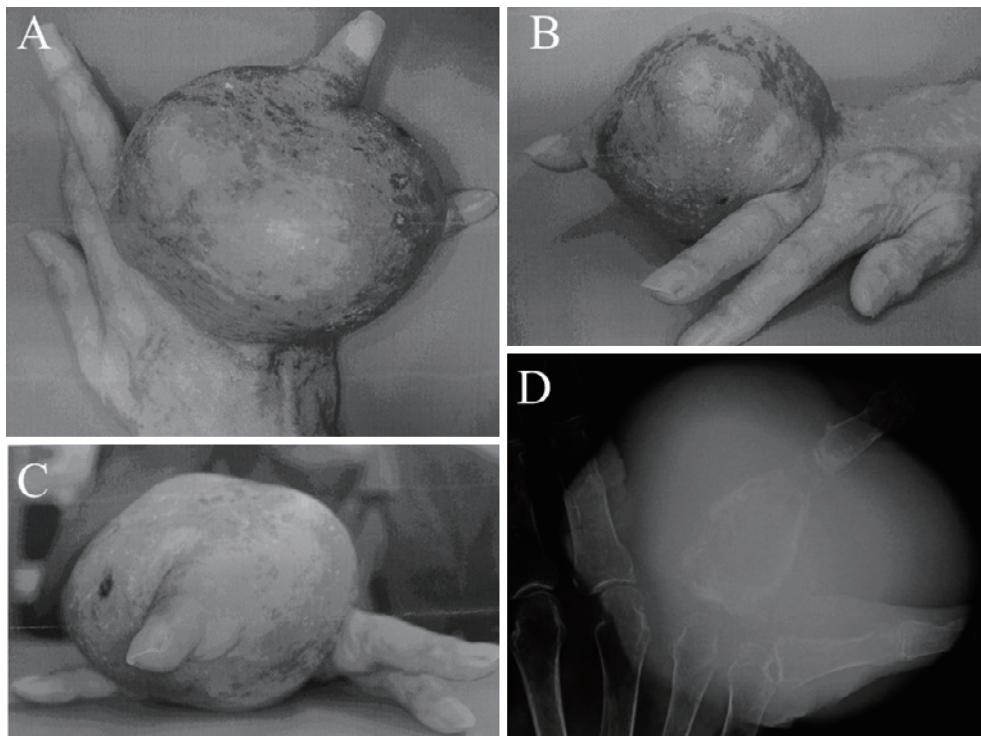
A ~ C: Preoperative photographs of the patient's right ring finger, showing a hard, bony, fusiform mass measuring 13 × 9 × 9 cm and involving the whole ring finger. D: Radiographs of PA view showing ballooning associated with the periosteal reaction in the proximal phalanx of the right ring finger and unusual inflammation of the subcutaneous radiotransparent region
